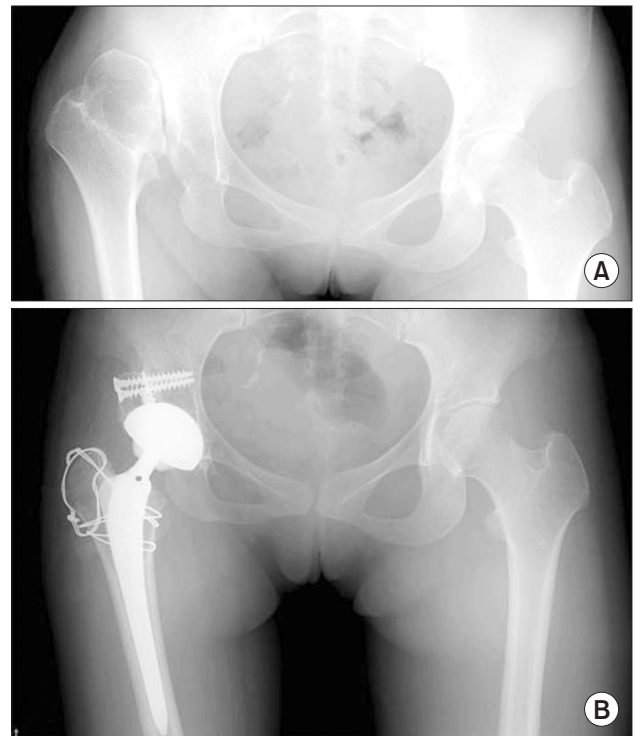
Preoperative and postoperative radiographs of a patient with Crowe type III high hip dislocation. (A) The preoperative radiograph shows a limb length discrepancy of 3.2 cm and acetabular dysplasia. (B) The postoperative radiograph shows stable implant fixation without osteolysis or loosening at 14.6 years after total hip arthroplasty using a ceramic-on-ceramic bearing.
